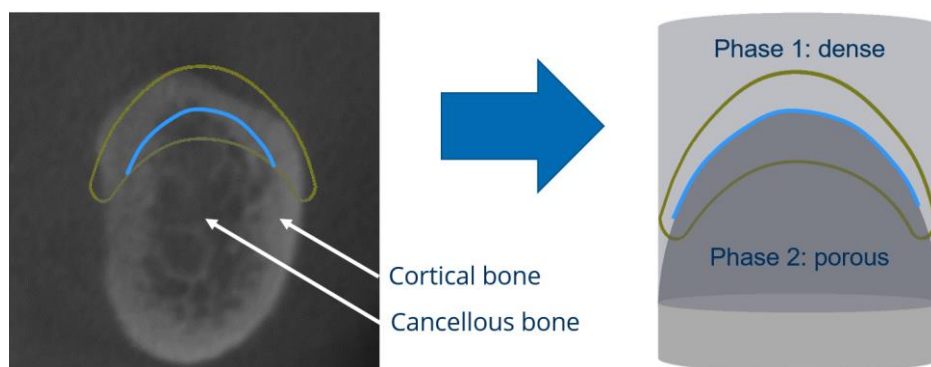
Left: CT cross-section (blue - border between bone types, yellow - replacing area); right: two density phases and individual outer implant shape (yellow) (Sembdner *et al.*, 2023)
